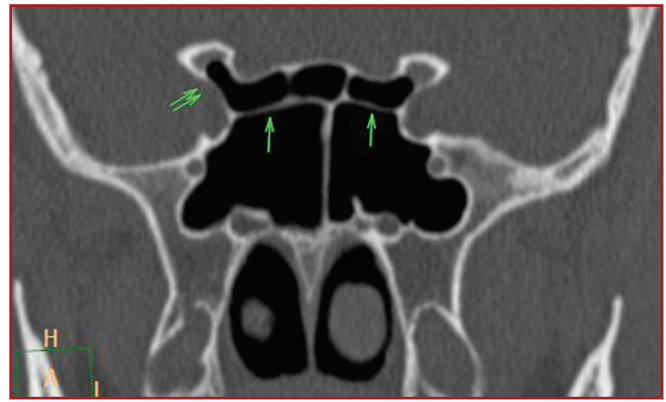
Coronal CT image shows Onodi cells on both sides (arrow). Pneumatization of the right anterior clinoid process is also seen (double arrow).
